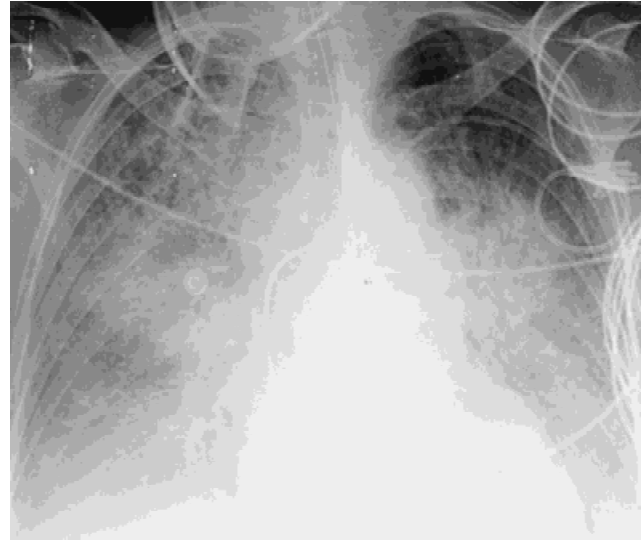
Day 3 in a patient with colon cancer and peritoneal carcinomatosis; a portable chest radiograph obtained at bedside reveals bilateral diffuse interstitial and air-space opacity with perihilar prominence, indicating pulmonary edema.
